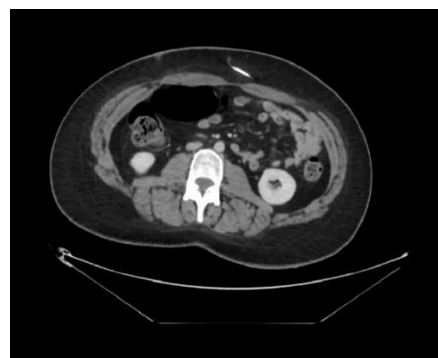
Further investigation with a CT Abdomen and pelvis showed multiple needles in the soft tissues.
